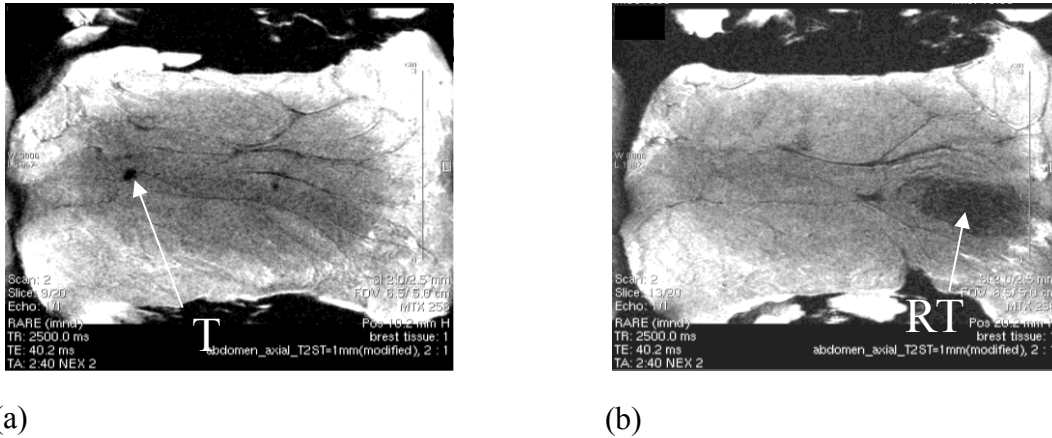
MR images of the left tumor and the right tumor pieces (T: left tumor, RT: right tumor).
